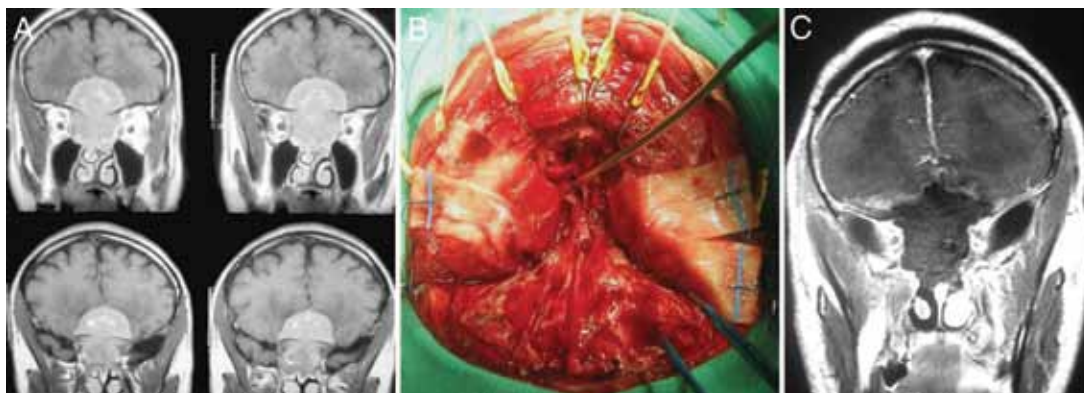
Case 4. A: Preoperative T1-weighted postcontrast coronal MR images showing a large anterior skull base meningioma extending into the nasal cavity. B: Intraoperative photograph showing the final view after removal of the tumor. C: Postoperative T1-weighted postcontrast coronal MR image demonstrating gross total-tumor resection at the 6-month follow-up.
